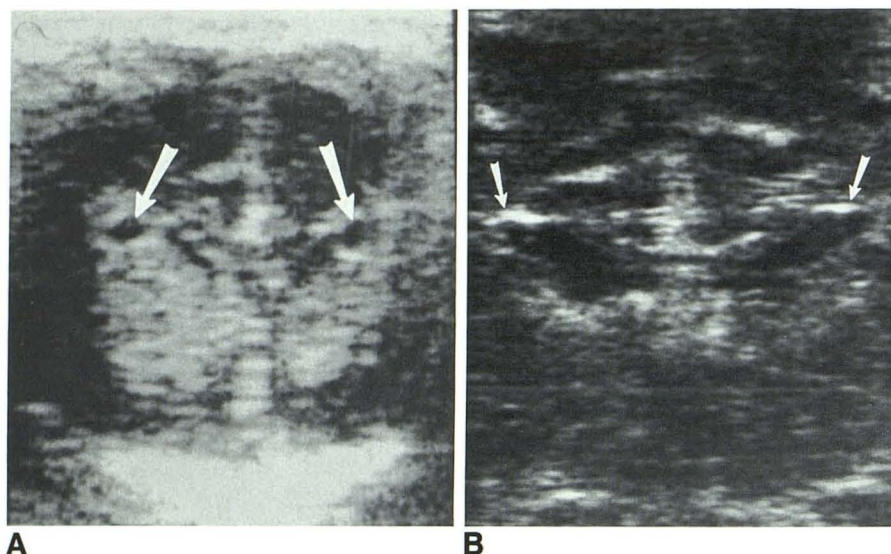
Case 7. Coronal sonograms.
